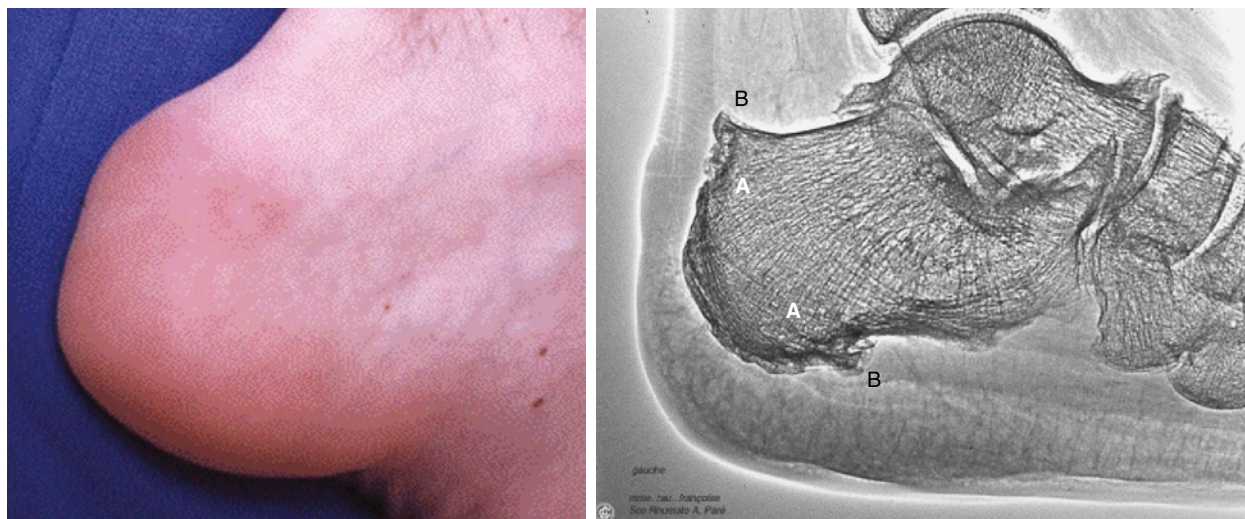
A, Clinical aspects of enthesitis of the Achilles tendon include swelling and redness of the insertion. B, Radiographic aspects of the Achilles tendon and plantaris fascia enthesitis include erosions (A) and enthesophytes (B).
